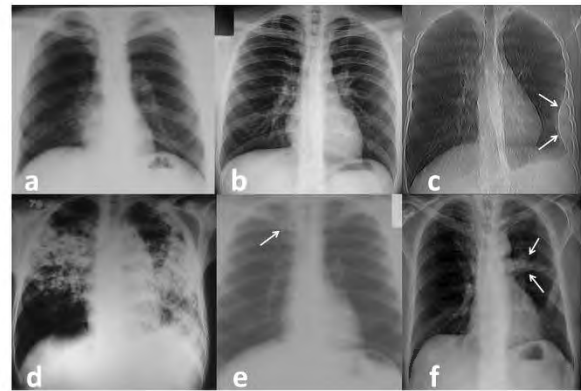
Conventional and digital microfilm samples of different cases which are confirmed during treatment and follow-up (CR : Computerized radiography, DR: Digital Radiography) a) An analog image evaluated as normal b) A DR image evaluated as normal. Counter to the resolution difference between the two films, there is no critical problem in evaluating the parenchymal aeration. c) In CR, observing pleural effusion with convex contours is present in lower lateral left zone (arrows). d) In the analog image, a case of bilateral central
